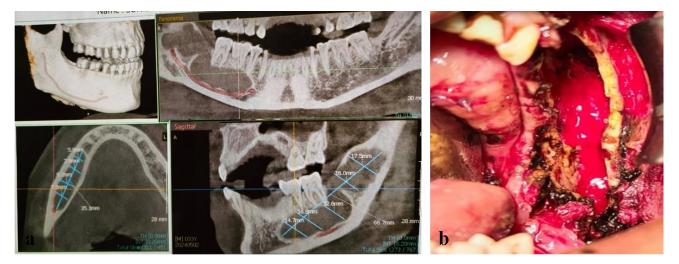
(a) OPG and CT scan revealed a radiolucent lesion extending anterior-posteriorly right side mandibular angle region and shows inferior alveolar nerve relationship with lesion; (b) cystic lesion of right mandibular angle region was enucleated along with chemical cauterization by modified Carnoy's solution (Case 2).
